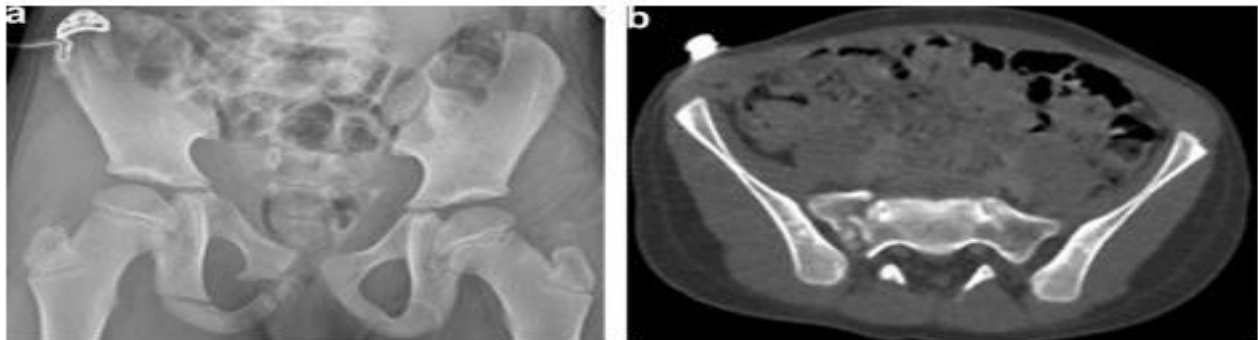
Sacrum fracture in a 6-year-old child that was missed on pelvis X-rays (3a), but detected on CT scan (3b) (Image courtesy of M. Panuel).
